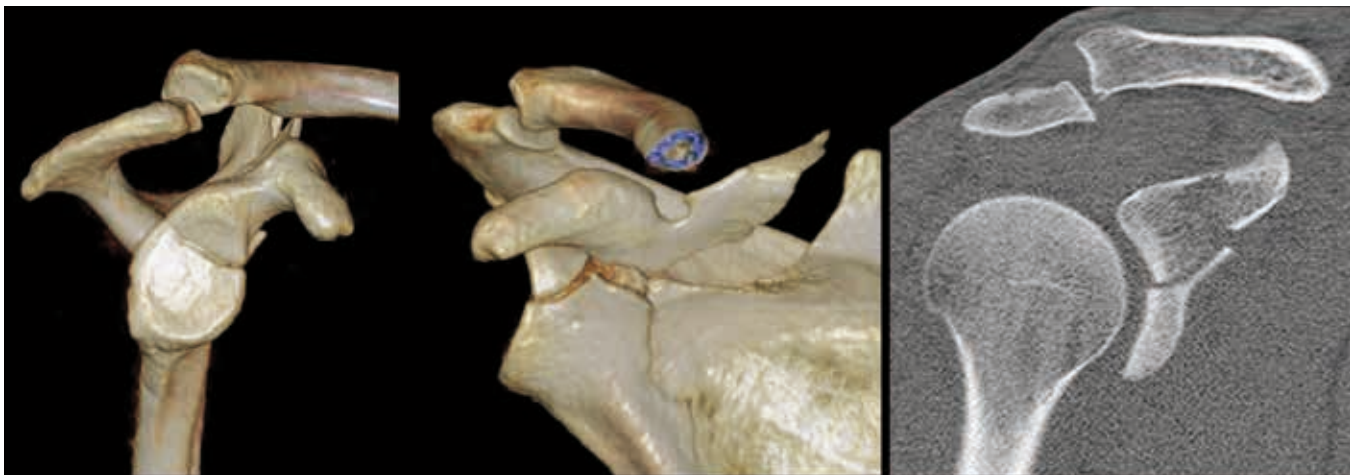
CT scan of the superior glenoid. The fracture line extends superior to the spinal pillar. The separated fragment is displaced medially, tilted into slight varus and rotated medially; the AC joint is subluxed.
